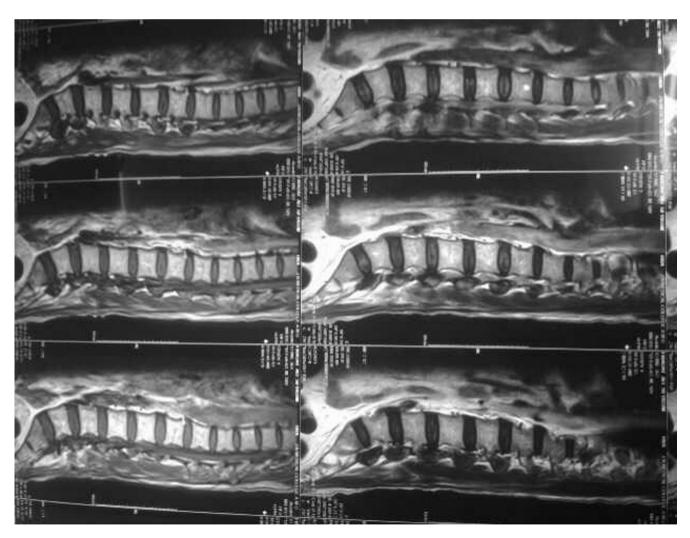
MRI showing no apparent abnormality.
